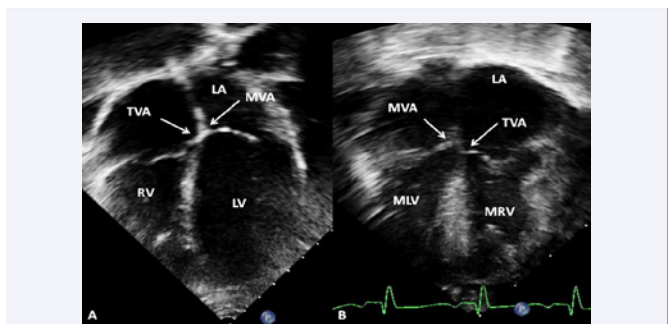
Selected video frames from apical four-chamber echocardiographic views of two infants. A. A normal ventricular relationship: note the higher level of attachment of the mitral valve (MVA) compared to the tricuspid valve attachment (TVA). B. Ventricular inversion: note the higher level of attachment of the mitral valve (MVA) on the right compared to the tricuspid valve attachment (TVA) on the left, indicating that the ventricles are inverted. LA, left atrium; LV, left ventricle; MLV, morphologic left ventricle; MRV, morphologic right ventricle; RA, right atrium; RV, right ventricle. Reproduced from reference [51].
